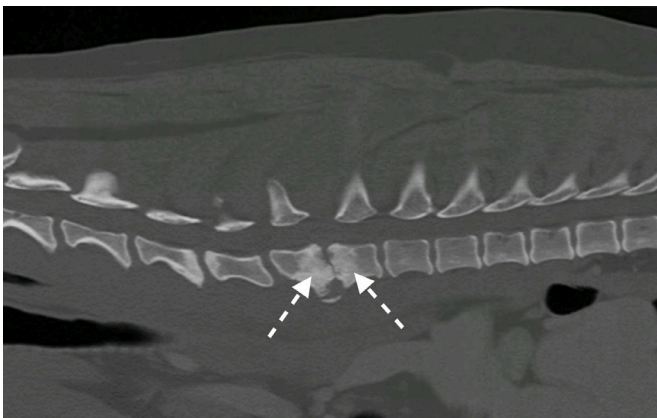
Sagittal CT of the cervicothoracic spine of case 4 demonstrating the irregular, osteolytic and sclerotic caudal C7 and cranial T1 vertebral endplates (dashed white arrows) and narrowing of the C7–T1 intervertebral disc space.
